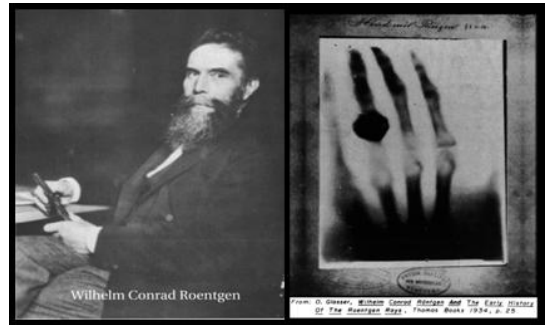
Wilhelm Conrad Roentgen and early x-ray of his wife’s hand, heralding the start of the modern era of medical imaging.
